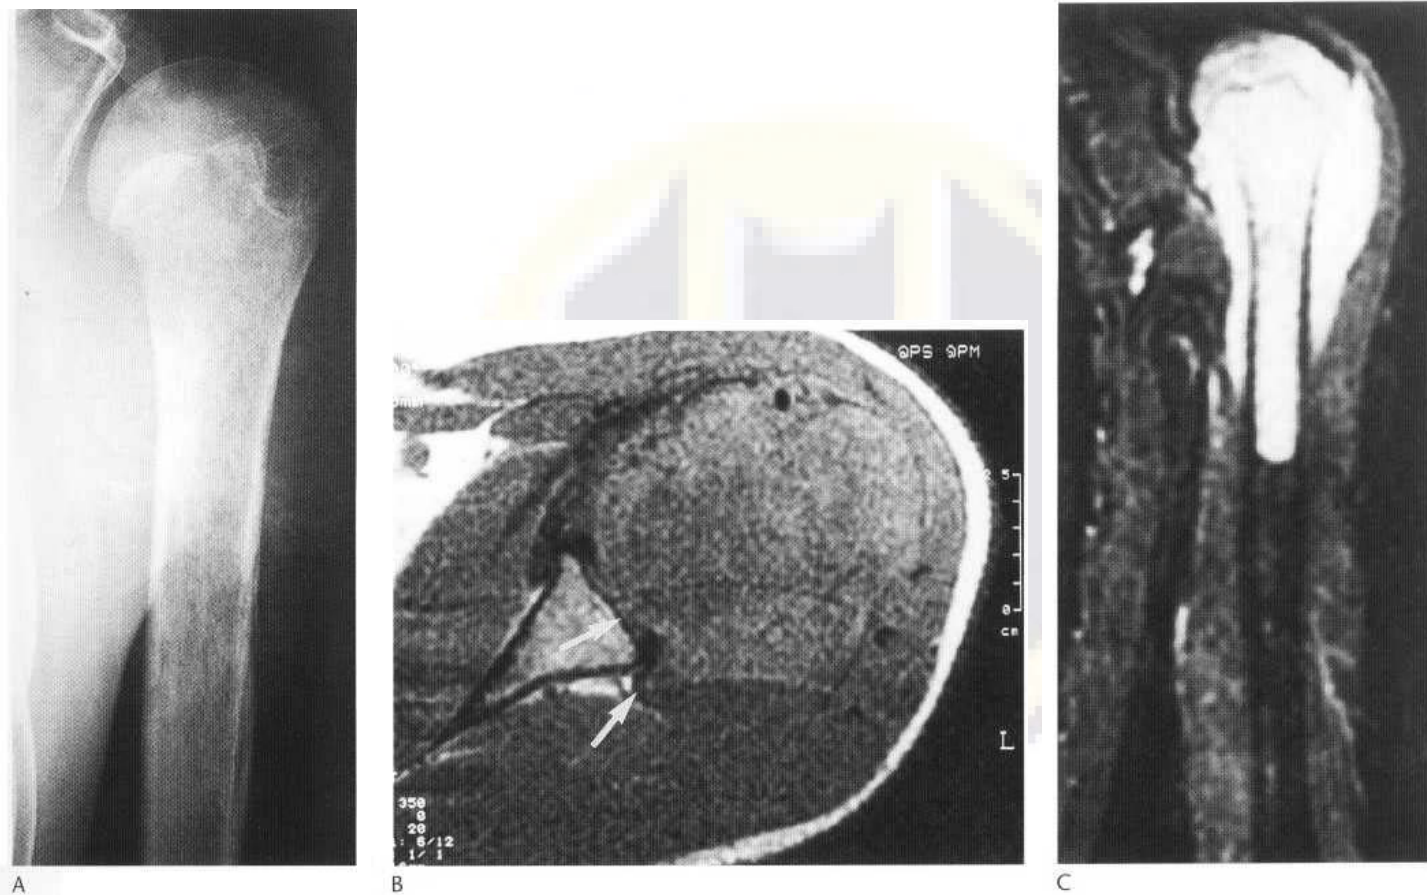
Osteosarcoma of the proximal humerus. (A) Conventional radiograph showing permeative bone destruction and focal areas of intramedullary sclerosis. A spiculated periosteal reaction is also evident. Axial T₁-weighted (B) and coronal STIR (C) images demonstrate the longitudinal extent of the tumour within the medullary canal and the extraosseous involvement, including extension into the shoulder joint (arrows).
